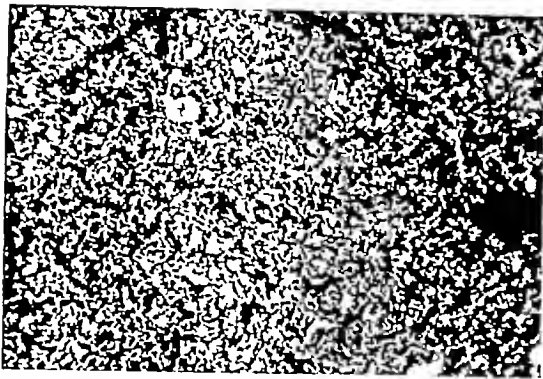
Hyperplasia of thyroid of opossum (13) induced by a meat diet, serving as a control to the X-ray treated thyroid in Figure 3. Magnification 60 times
